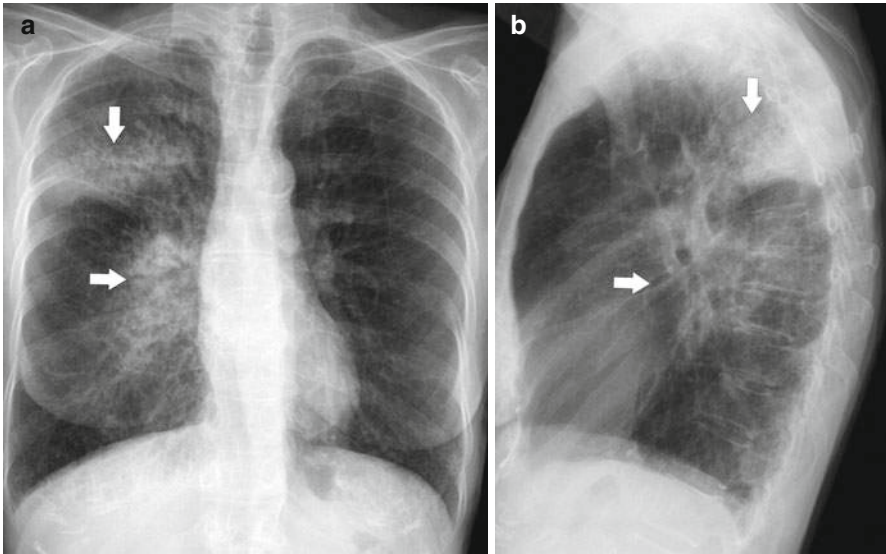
Pneumonia in an asthmatic patient. Chest X-ray posteroanterior (a) and lateral (b) views show hyperinflated lungs with flattened diaphragms and multifocal pneumonia (arrows) in the right lung
